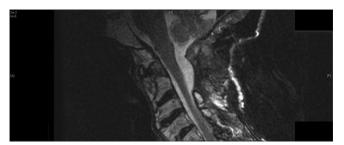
A 2-year postoperative MRI demonstrating complete resolution of retroclival lesion as well as no spinal cord compression
